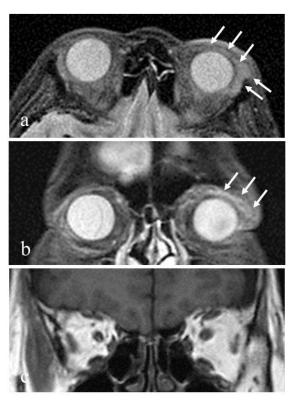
Axial (a) and coronal (b) T2-weighted MRI showed swollen left lacrimal gland extending to the upper eyelid (arrows). The extraocular muscles were not enlarged (c: coronal T1-weighted MRI)
